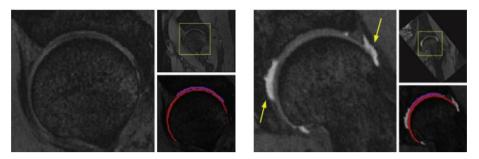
Acquisition of data from MRI or CT images (Xia et al., 2014)
